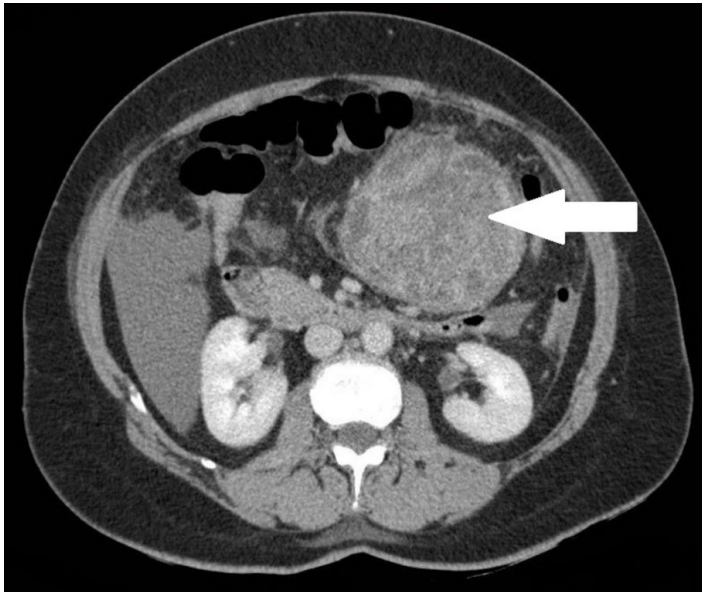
Computed tomography of the abdomen and pelvis at level of renal hilum showing a large, heterogeneous exophytic mass of 9.2 x 9.5 x 9 cm as indicated by the white arrow, later determined to be a gastrointestinal stromal tumor.
